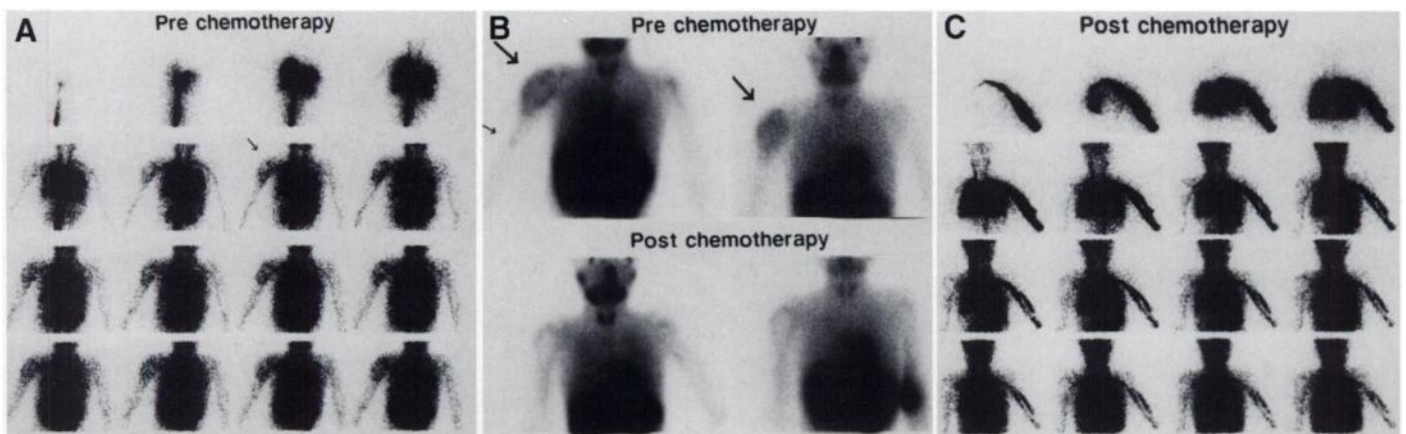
An 8-yr-old boy with osteosarcoma in the right proximal humerus (Patient 2). (A) Radionuclide angiography with ^{99m}Tc -MIBI demonstrates increased perfusion of the tumor (arrow). (B) Prechemotherapeutic ^{99m}Tc -MIBI (left upper) and ^{201}Tl (right upper) accumulated in the lesion (large arrows), but only ^{99m}Tc -MIBI scintigraphy discloses bone marrow extension to the humeral shaft (small arrow). After chemotherapy, both tracers show (B) markedly decreased lesion uptake and (C) perfusion. Complete tumor necrosis was verified after resection of the tumor.
